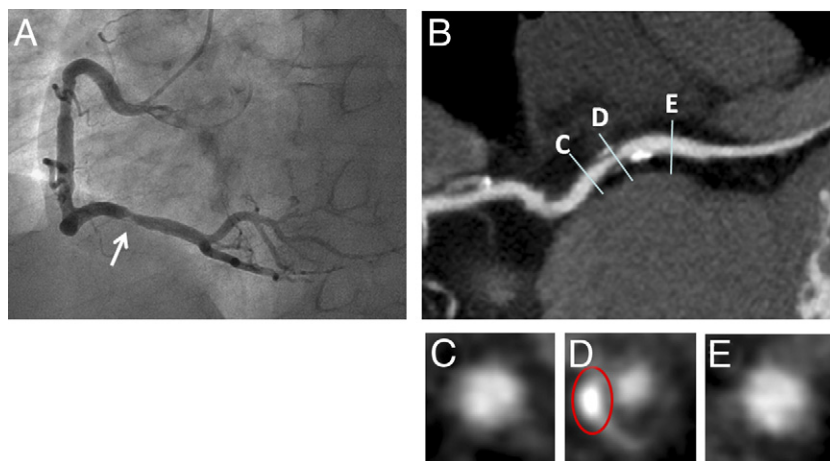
CT Characteristics of Culprit Lesion in Patient With Post-PCI TnT Elevation ≥ 3 Times Upper Limit of Normal
